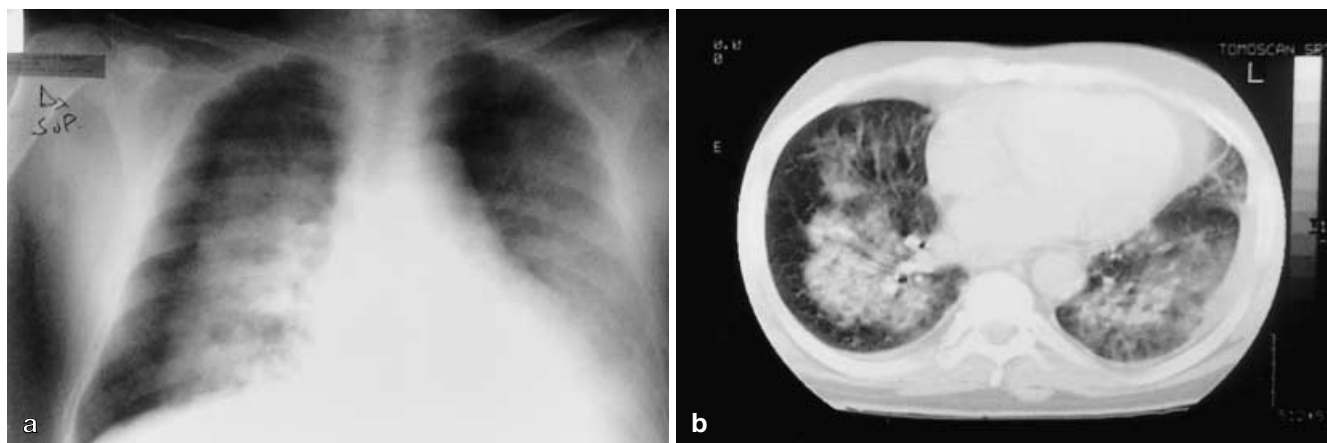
This patient was admitted with respiratory distress after a few days of low grade fever and no chest pain. Plain chest X-ray raised the possibility of a right pneumothorax. In the right hemithorax opacities spared the peripheral region of the lung; in the left hemithorax the opacities were more diffuse. Two-dimensional echocardiography revealed severe mitral regurgitation. The CT scan clearly shows the butterfly distribution of the opacities
